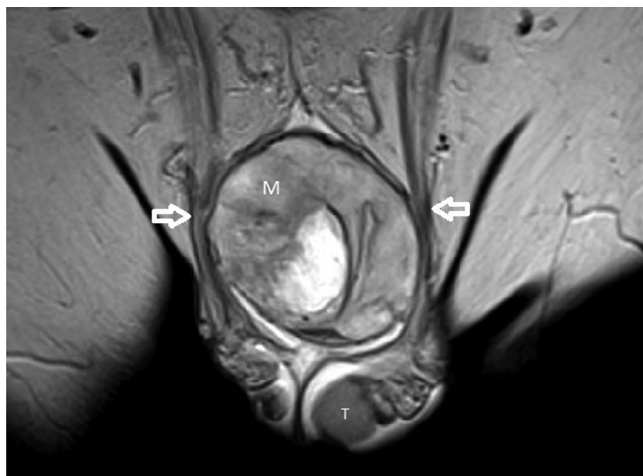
Coronal T2-weighted TSE magnetic resonance imaging demonstrates a large mass (M) with an internal area of hyperintense necrosis of the penile shaft involving the corpora and abutting the spermatic cords (arrows). T = testis, left; TSE = turbo spin echo.
